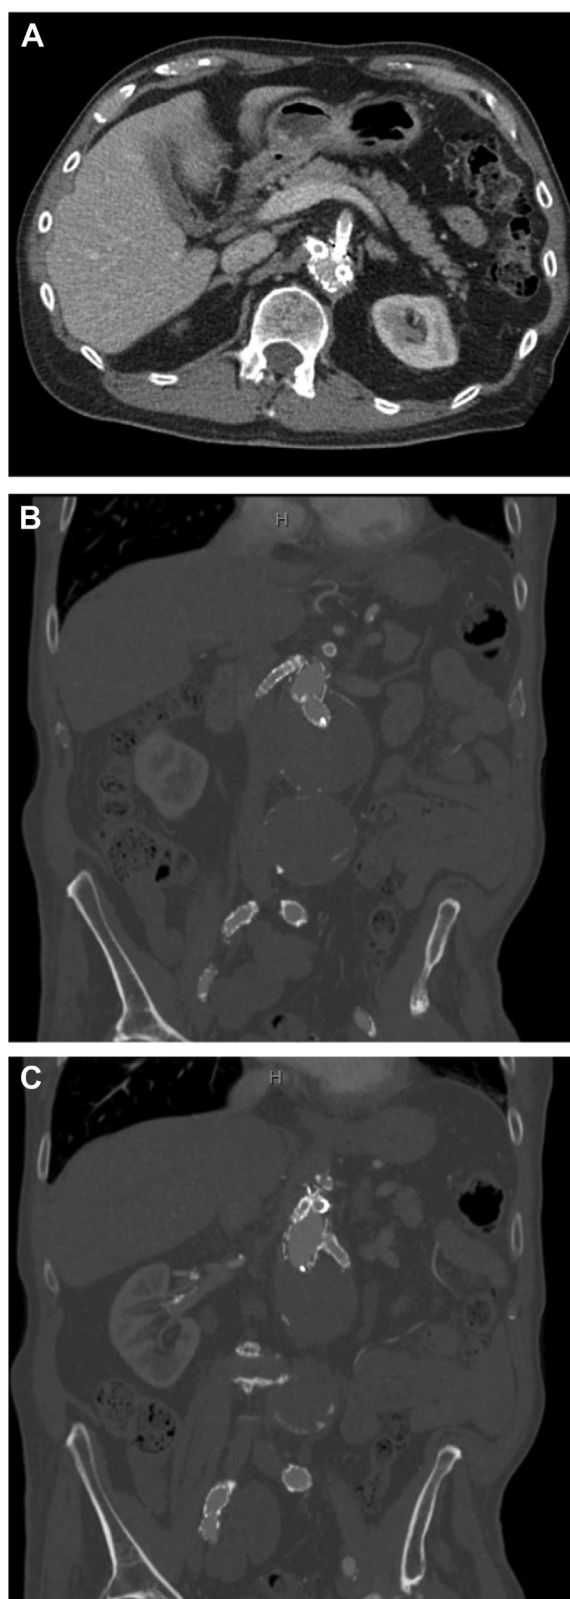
Representative (A) axial, (B), coronal, and (C), deeper coronal images of a one month computed tomography angiography scan following modification and implantation of Gore Conformable device.
